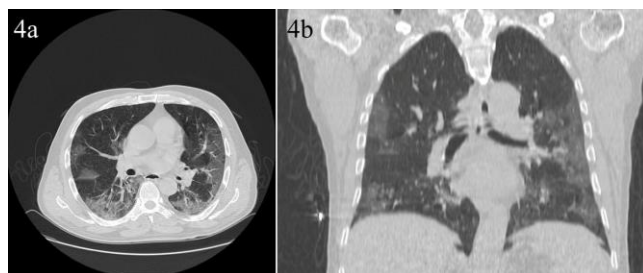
Axial and coronal plane images of Chest CT. Bilateral, ground glass densities in the form of consolidated areas, more prominent in the middle-lower zones were seen
